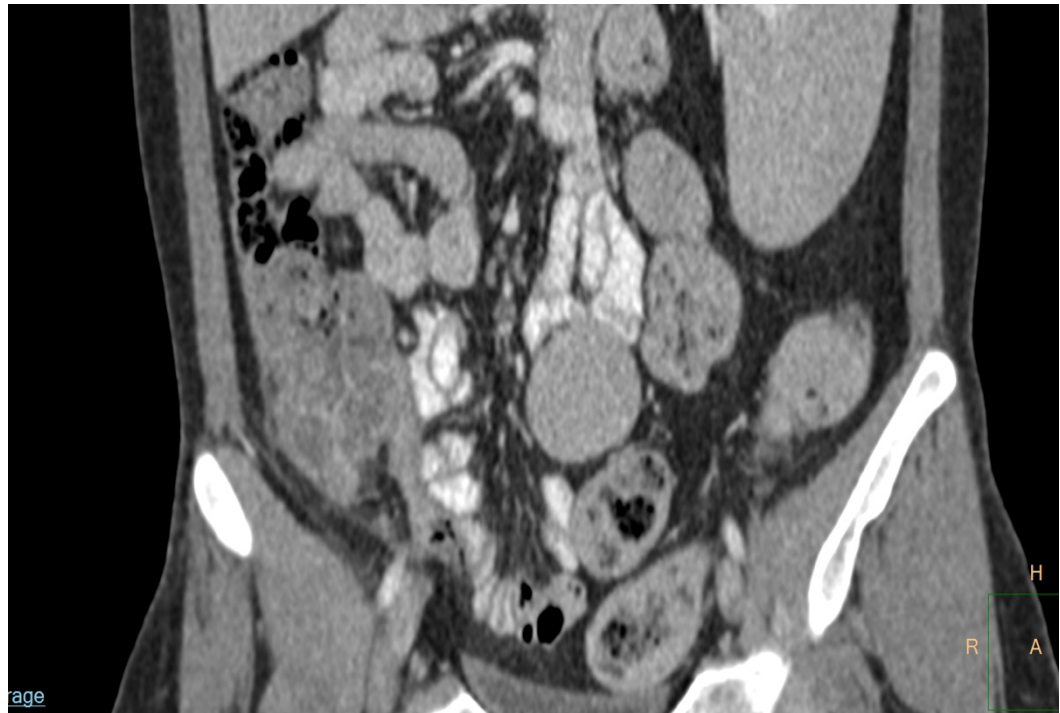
Abdominal CT scan (frontal and cross section) showing the edematous cecum and appendix
